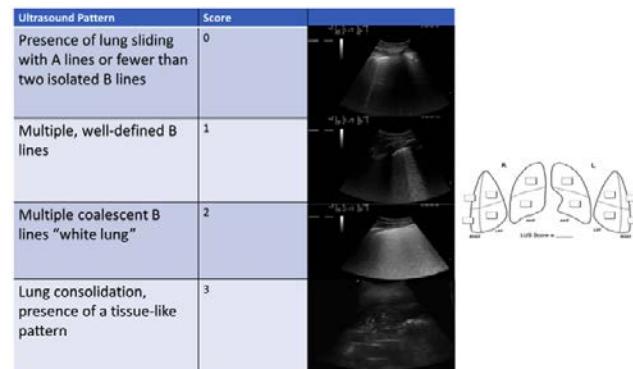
Ultrasound scan was taken in six regions for each lung (superior and inferior areas in the anterior, lateral, and posterior fields using anterior and posterior axillary lines as landmarks). Four ultrasound aeration patterns were defined in each region: presence of lung sliding with A lines or fewer than two isolated B lines (0); multiple, well-defined B lines (1); multiple coalescent B lines or white lung (2); lung consolidation (3). LUS scores were calculated as the sum of all.
